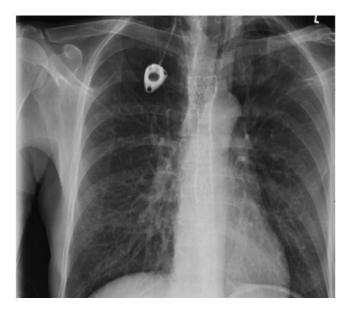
AP chest radiograph completed shortly after placement of 2 esophageal SEMS which demonstrated appropriate positioning.
